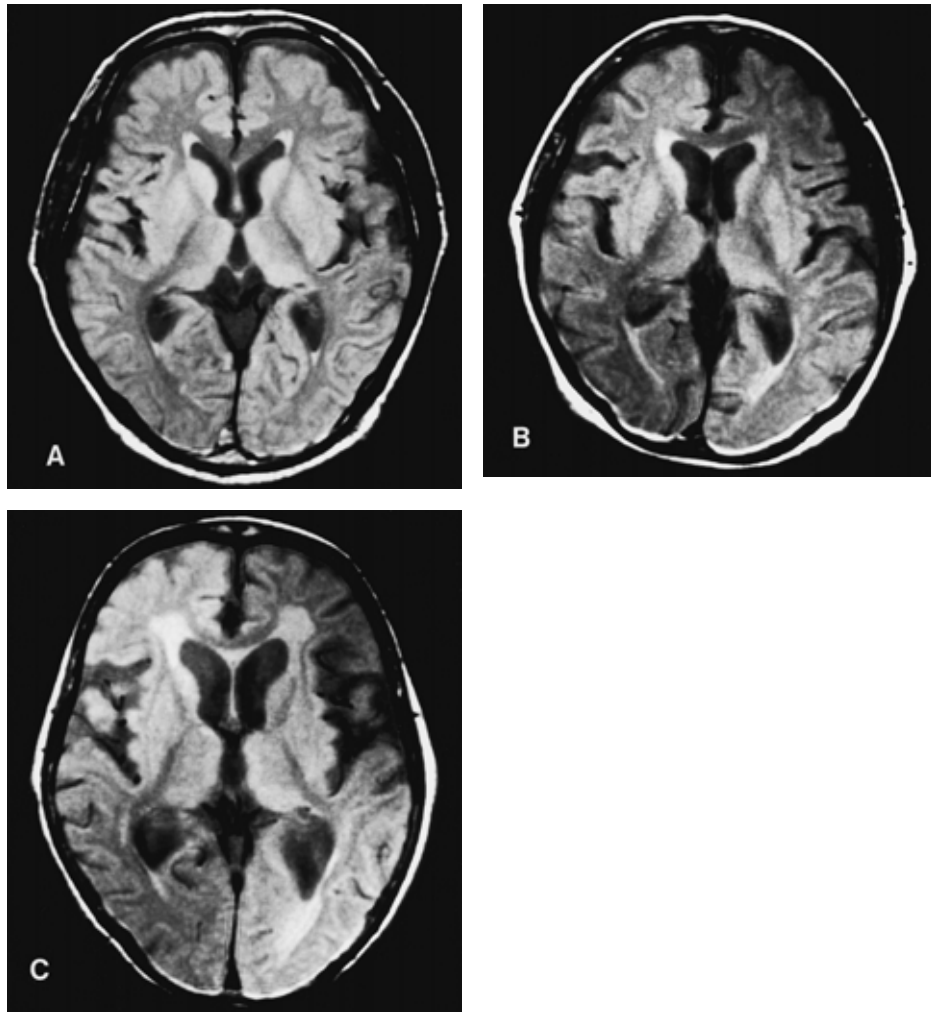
White matter surrounding the frontal horns on FSE proton density weighted MR images. A: Triangular type; The triangular-shaped high signal intensity region is depicted just adjacent to the frontal horns bilaterally. B: Oval type; Oval-shaped high signal intensity region is depicted surrounding the frontal horns bilaterally. The area of high signal intensity extended into the white matter beyond the triangular-shaped high signal intensity region but not into the subcortical white matter. C: Irregular type; Irregularly shaped high signal intensity region surrounding the frontal horns bilaterally. The high signal intensity extended into the corpus callosum or subcortical white matter.
